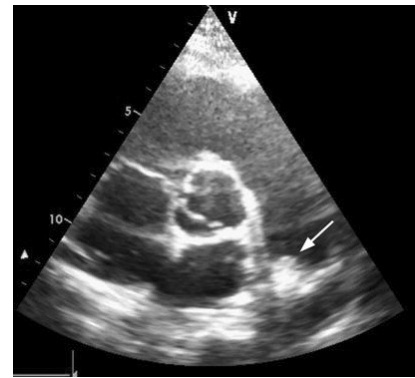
Transthoracic echocardiogram showing a thrombus at the fork of the pulmonary artery (arrow).
